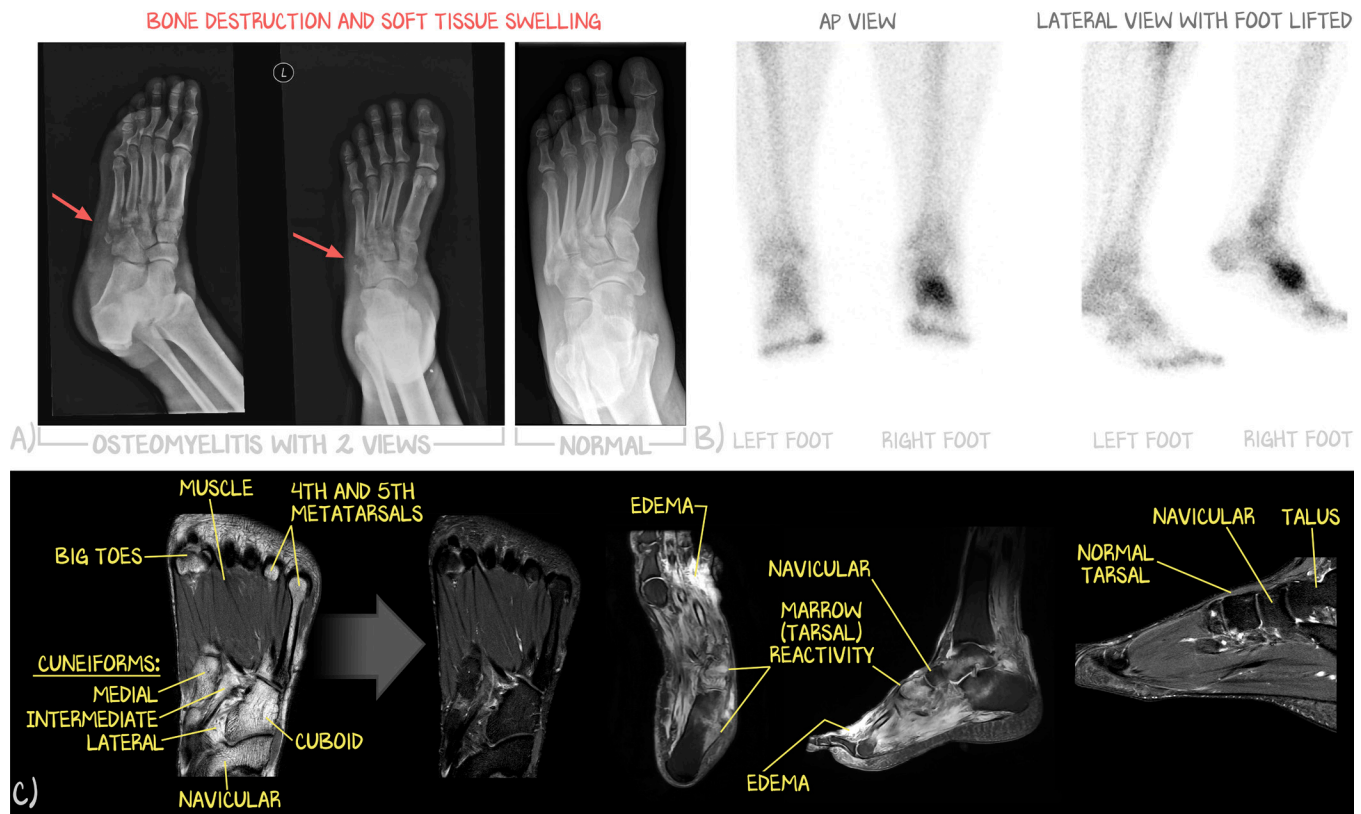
Radiographic Osteomyelitis
